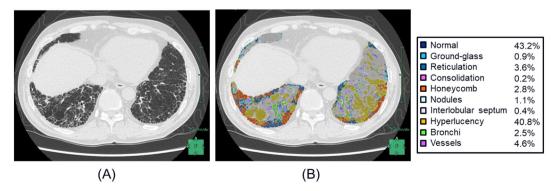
Quantification of lung lesions by artificial intelligence-based quantitative computed tomography image analysis software. (A) A high-resolution computed tomography scan and (B) the corresponding overlaid image.
